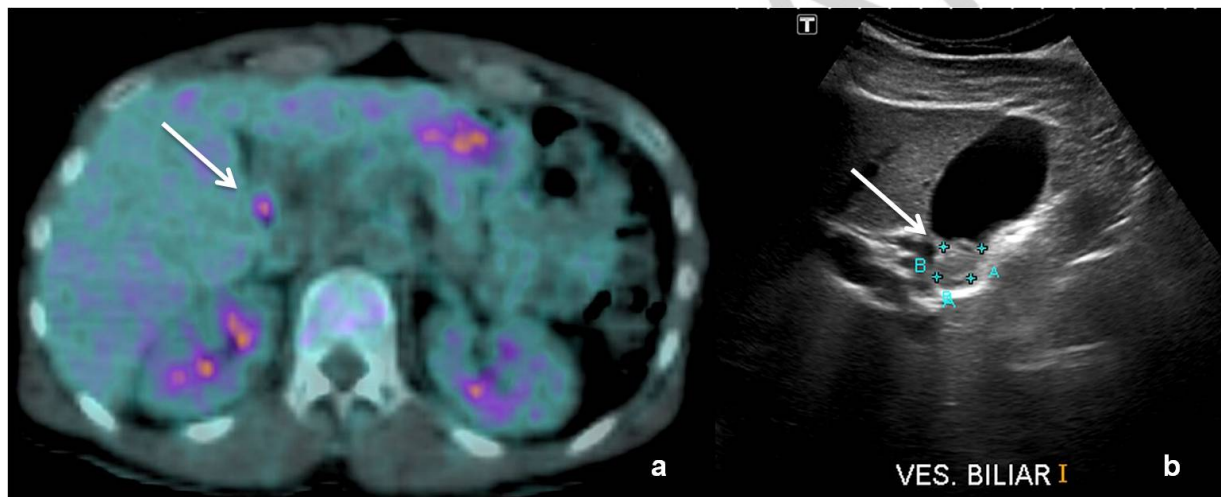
(a) PET/CT shows focal area of increased radiopharmaceutical uptake in the topography of the gallbladder infundibulum (white arrow in a) which corresponding to (b) a heterogeneous nodule in the ultrasound study (white arrow in b).
